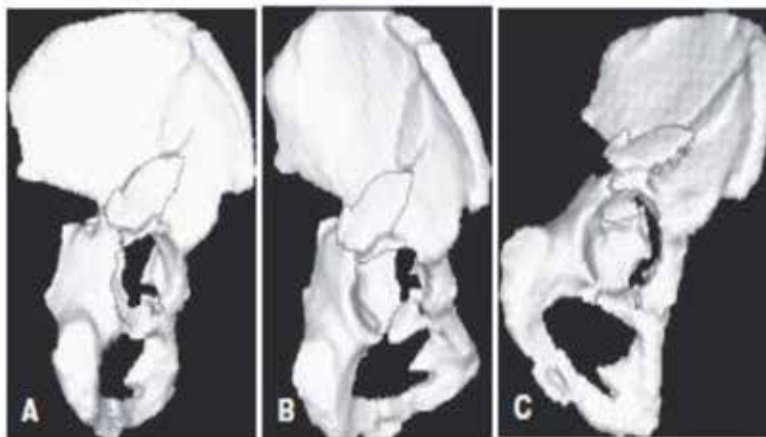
Three-dimensional CT reconstruction of both-column fracture.
